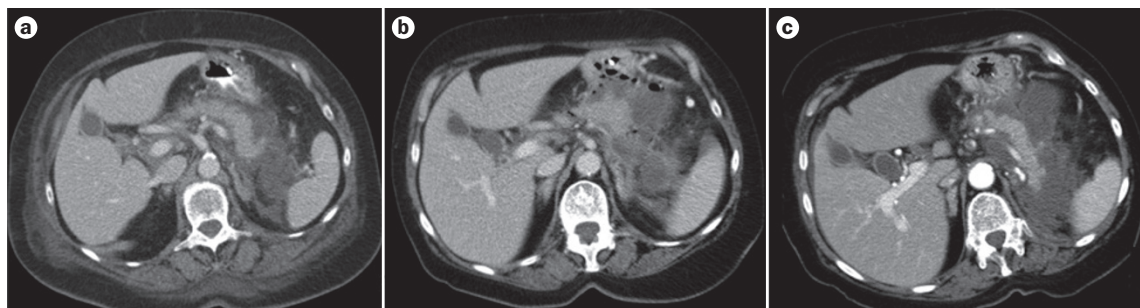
A patient with acute pancreatitis. a | Contrast-enhanced CT image of a patient 1 week after onset of symptoms. The pancreas enhances completely and is surrounded by either an acute peripancreatic fluid collection or extrapancreatic necrosis. Distinguishing between the two is difficult at this point. b | The same patient 3 weeks after symptoms onset. The enhancing pancreas is surrounded by a heterogeneous collection of dense fluid and fat. This finding is typical for extrapancreatic necrosis. c | The same patient 5 weeks after symptom onset. The patient suddenly developed pain in the upper abdomen. CT demonstrated an acute necrotic collection with a smaller size than the previous CT had shown, and gas bubbles inside the acute necrotic collection. These findings suggested a spontaneous fistula between the acute necrotic collection and the stomach. During endoscopy the fistula was visualized. Subsequently, endoscopic transgastric necrosectomy was performed and the patient recovered.
